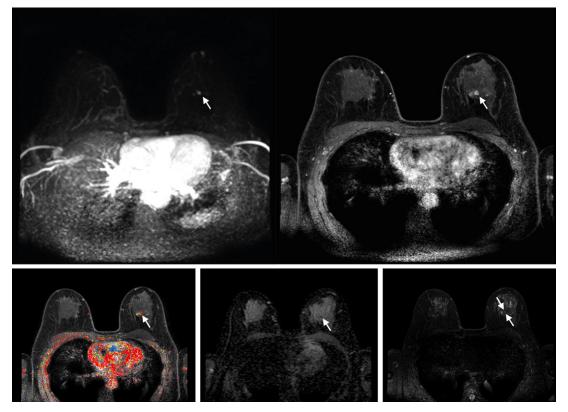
Abbreviated axial MRI images show a 7-mm irregular mass with irregular margin (arrows) in the right upper inner quadrant with early rapid enhancement (Breast Imaging Reporting and Data System category 4 [suspicious for cancer]). The participant was recalled and underwent an MRI-guided vacuum-assisted biopsy that showed sclerosing adenosis with microcalcifications and usual ductal hyperplasia and focal apocrine metaplasia. On the full-protocol images (not shown), the lesion was T2-weighted hypointense and showed diffusion restriction and washout kinetics in the delayed phase, characteristics that would not have reversed the decision to recall the participant.
